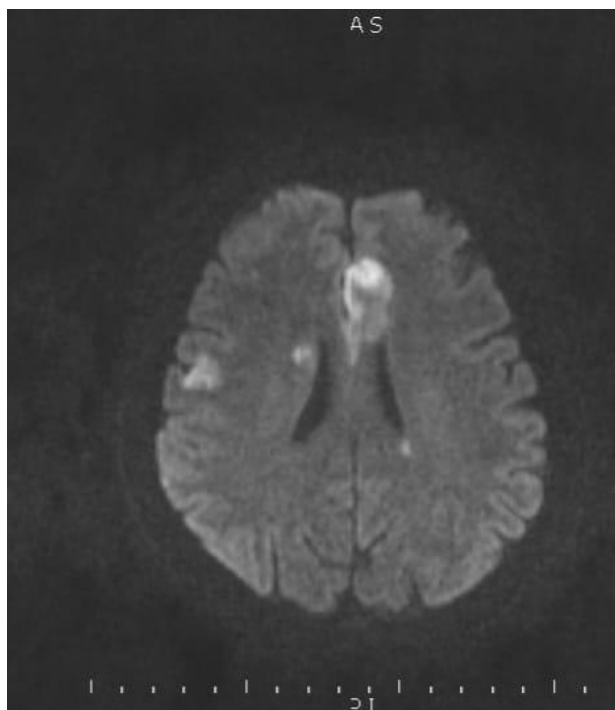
Regions of intracerebral occlusion on MR image sections-central and frontal lobes
